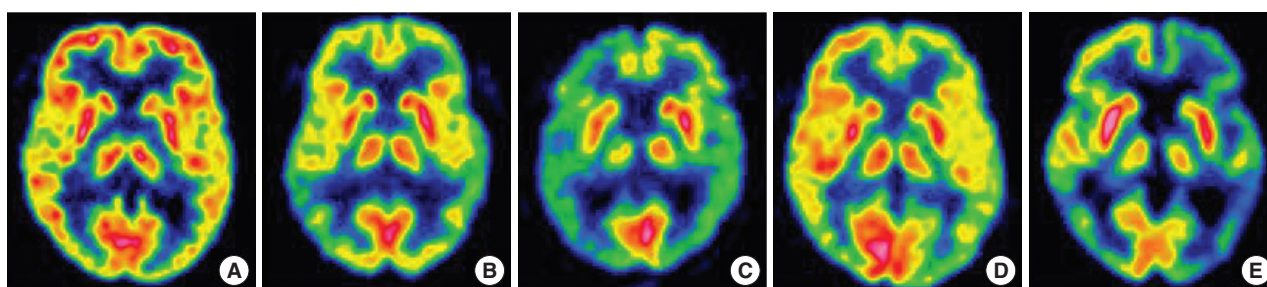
Comparison of brain FDG-PET images from a cognitively normal control and four patients with EOAD. FDG-PET images (B-E) show variable degrees of hypometabolism in temporoparietal and frontal cortex, which are typical for Alzheimer's disease. (A) a 55-yr-old healthy Korean with a K-MMSE score of 30, (B) patient 2; 3 yr after the first symptom with a K-MMSE score of 22, (C) patient 3; 4 yr after the first symptom with a K-MMSE score of 4, (D) patient 5; 3 yr after the first symptom with a K-MMSE score of 18; (E) patient 6; 3 yr after the first symptom with a K-MMSE score of 11.
